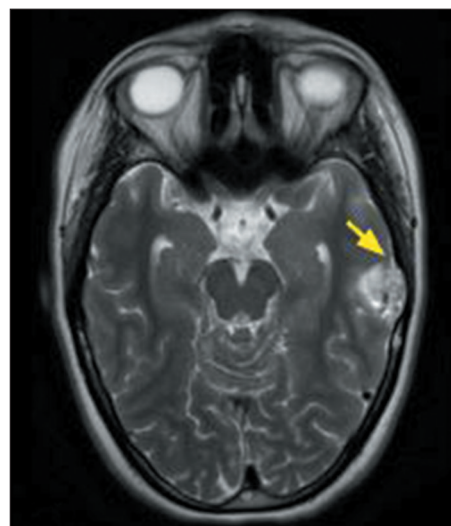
MRI examination of a 20-year-old female patient diagnosed with a polymorphous low-grade neuroepithelial tumor of the young. A T2-weighted sequence showing a well-defined intra-axial temporal lesion on the left, with high signal intensity and containing small cystic areas, the slow growth of which led to remodeling of the cranial vault (arrow).
